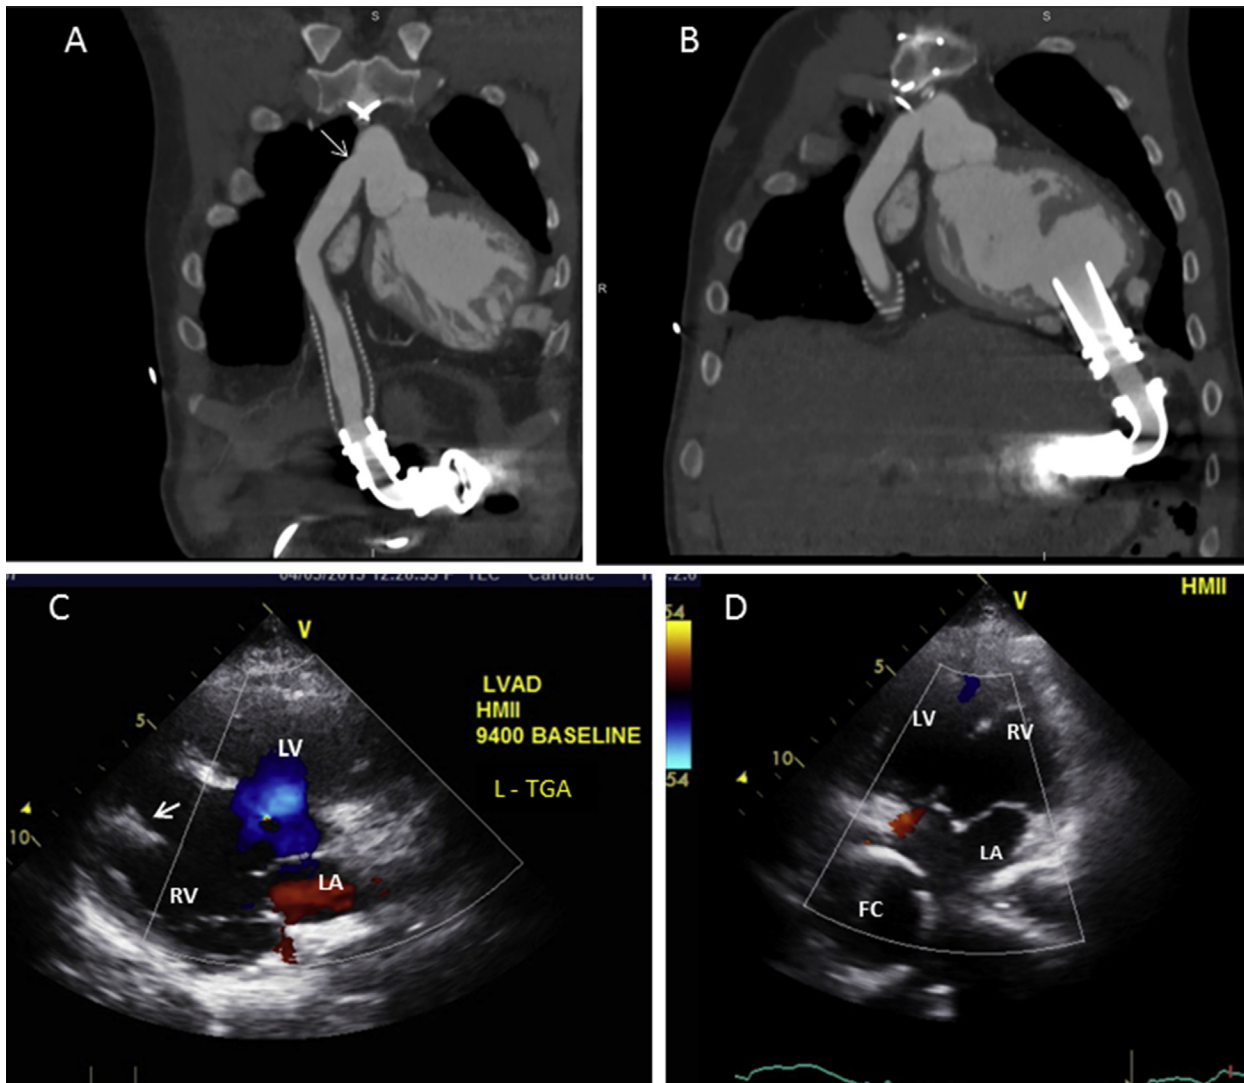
Complementary X-ray CT (A, B) and echocardiogram (C, D) from a 25-year-old man with single ventricle physiology: L-transposition of the great arteries (L-TGA), complete atrioventricular septal defect (AV canal defect) and subpulmonic stenosis, and a nonfenestrated Fontan conduit (placed at age 5 years). Although he initially received an HM-II LVAD for destination therapy, he eventually underwent cardiac transplantation after 2 years of VAD support (BTT conversion). (A) Coronal-plane CT shows a normal outflow graft, including the aortic anastomosis (*arrow*). (B) Near-sagittal-plane CT reveals an unobstructed inflow cannula. (C) Parasternal long-axis view of a nonrestrictive VSD (*blue color flow*) and inflow cannula (*arrow*) within the morphologic RV. See also [Video 47](#). (D) Apical 4-chamber view showing the Fontan conduit (FC). See also [Video 48](#).
